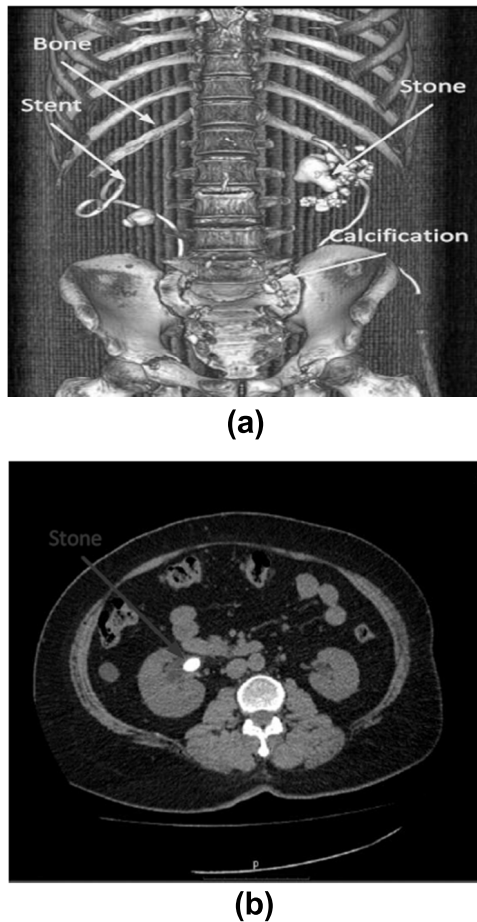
(a) Stent, Stone, Calcification and bone on CT Image (b) CT Slice.
